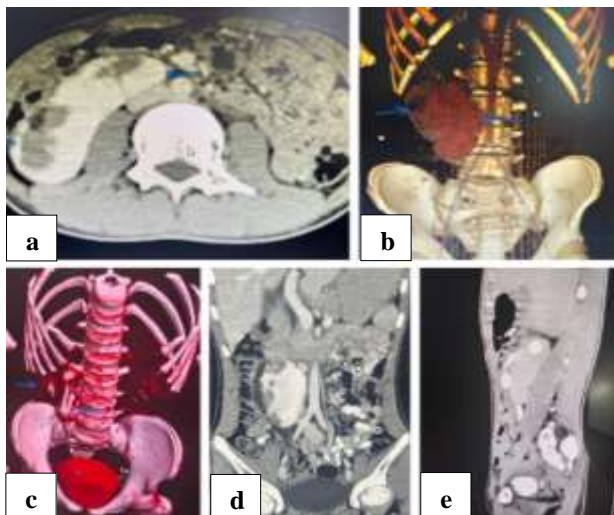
(a) Axial section, (b) and (c) volume rendered 3D reconstruction showing crossed fused renal ectopia with pelviccalceal system of both kidneys (shown by arrows), (d) coronal view of venous phase, and (e) sagittal view of excretory phase in contrast CT scan showing single ureter draining both kidney on ipsilateral side.
